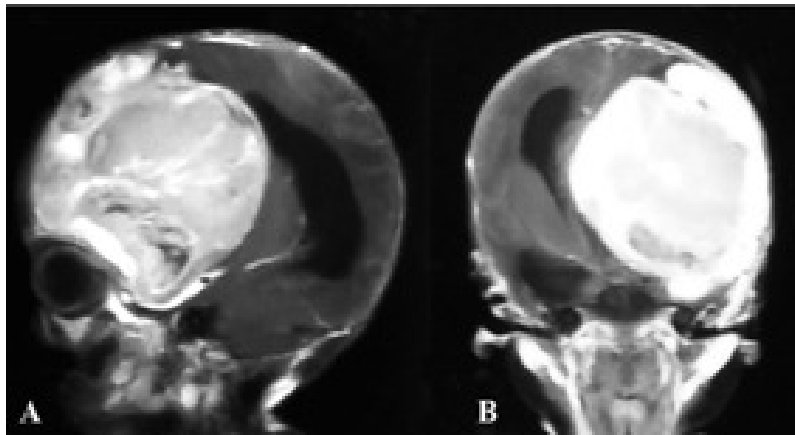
(A), (B) Sagittal and coronal T1-weighted magnetic resonance imaging scans with gadolinium contrast revealed a huge, heterogeneous, enhanced solid mass with a cystic lesion in the left frontal lobe, along with massive ventricular dilatation.
